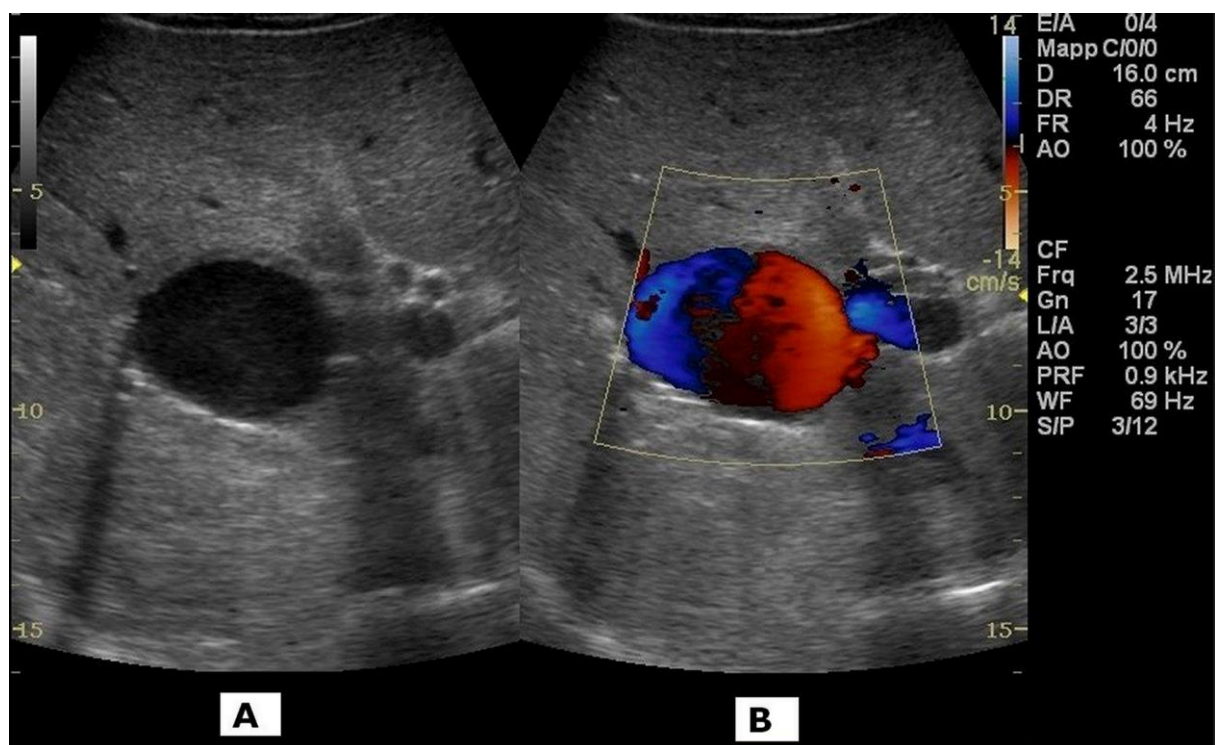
Ultrasonographic examination of the upper abdomen (GE Logiq P5 PRO instrument with a 4 MHz transducer, operating at 2.5 MHz for Doppler analysis) detected an anechoic space-occupying lesion of the liver, with parietal enhancement, measuring 4 x 4.5 cm (*Figure 1a*). Color-Doppler integration of this mass showed a “korean-flag pattern” suggestive of a low-flux aneurysm (*Figure 1b*).
